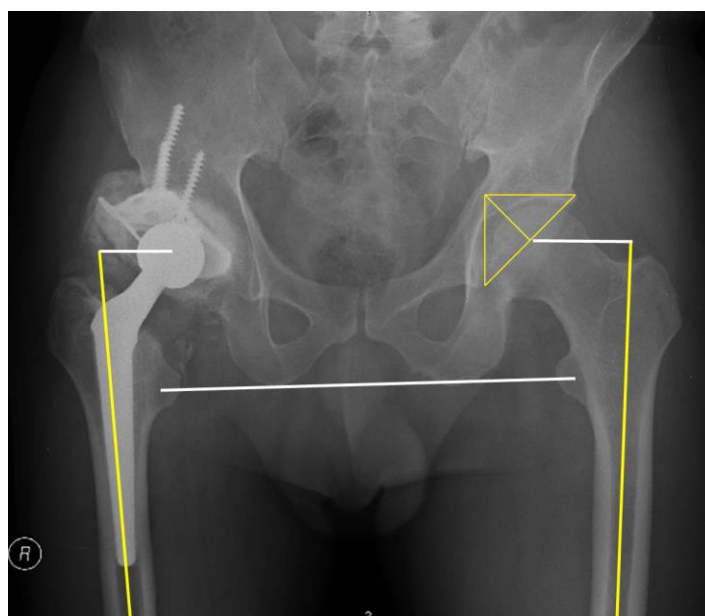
Postoperative THA radiograph at follow-up period of 4-years showing an acceptable position of the hip's center of rotation and the lateral and vertical offsets, a correct inclination of the cemented polyethylene cup, and approximation of the leg lengths equality.
